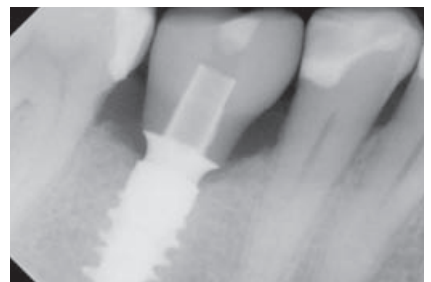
Periapical X-Ray 6 months follow-up.
